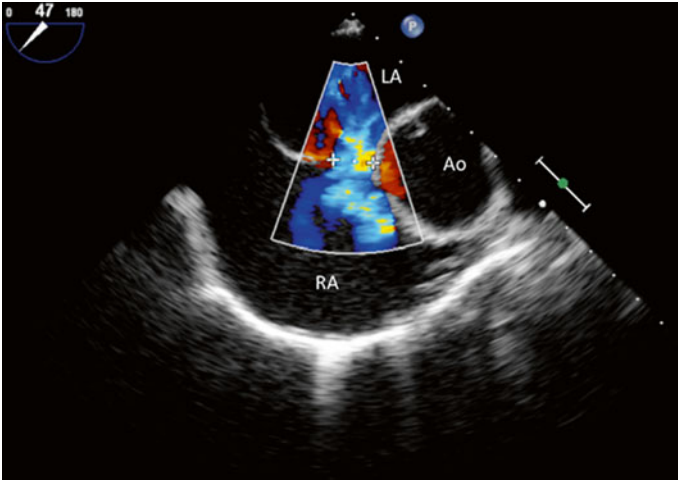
Trans-oesophageal echocardiography, colour Doppler: markers showing sizing using colour Doppler. *RA* right atrium, *LA* left atrium, *AO* aorta
